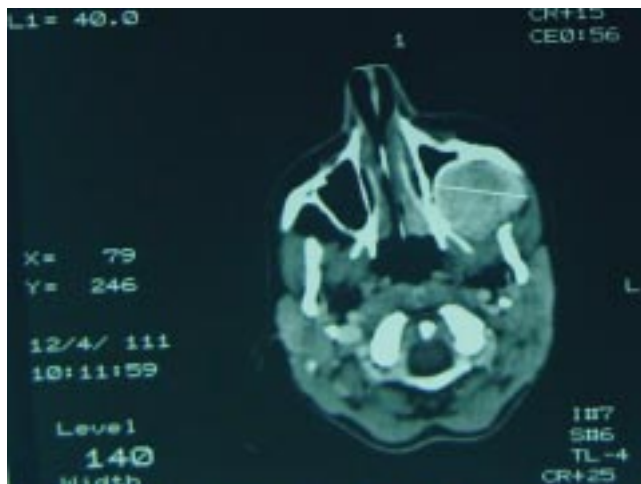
Computed tomography scan showing displacement of adjacent tissue planes.
